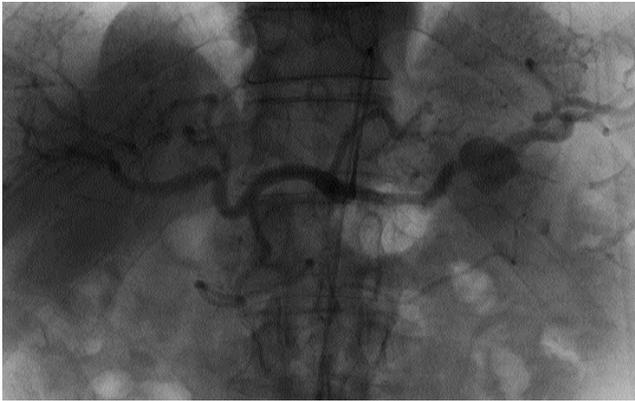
CT transcatheter mesenteric angiogram.
